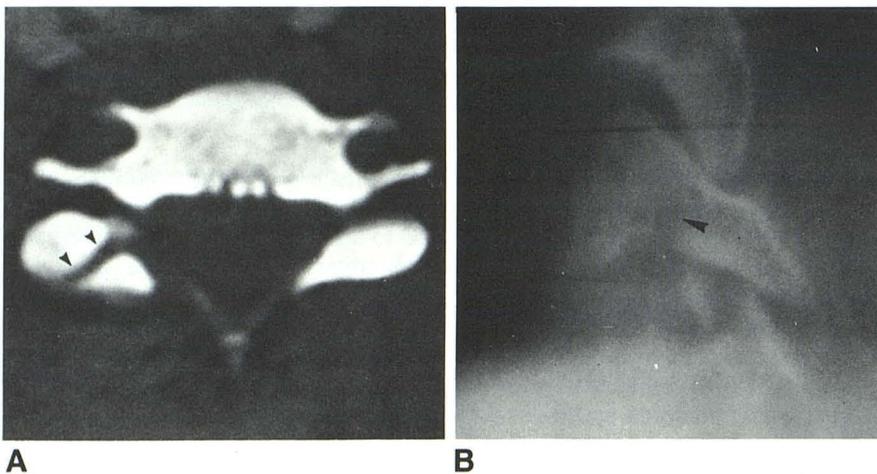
Articular pillar fracture. CT scan (A) shows fracture line (arrowheads), which should not be misinterpreted as a joint. Pluridirectional tomogram (B) confirms fracture (arrowhead).
